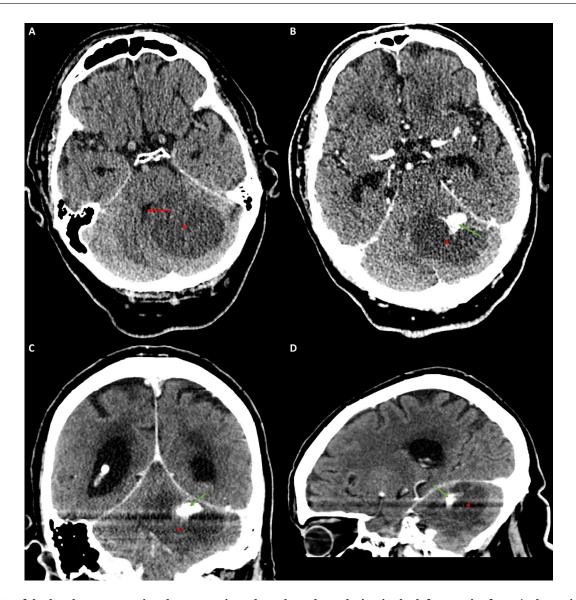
CT of the head at presentation demonstrating a large hypodense lesion in the left posterior fossa (red asterisks), with an associated mural nodule along the superolateral margin (red arrow; A). The mural nodule demonstrated homogeneous postcontrast enhancement (green arrow; B-D) (Color version of the figure is available online.).
